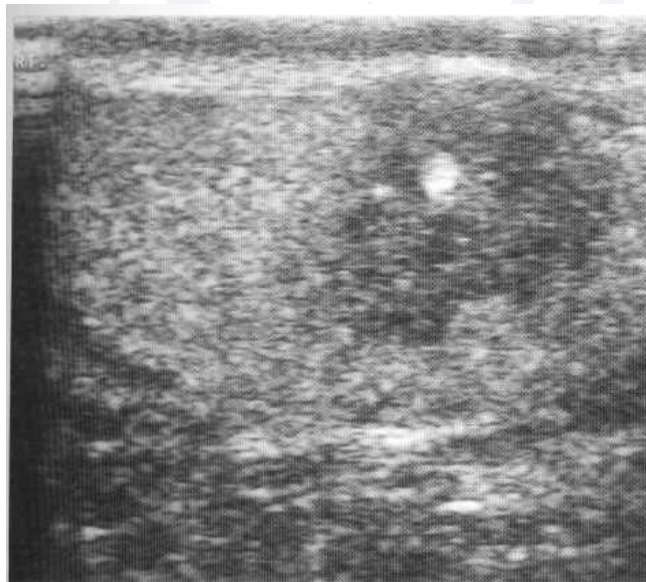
Ultrasound of NSGCT which is echo-poor but relatively ill-defined and containing at least one area of prominent calcification.
